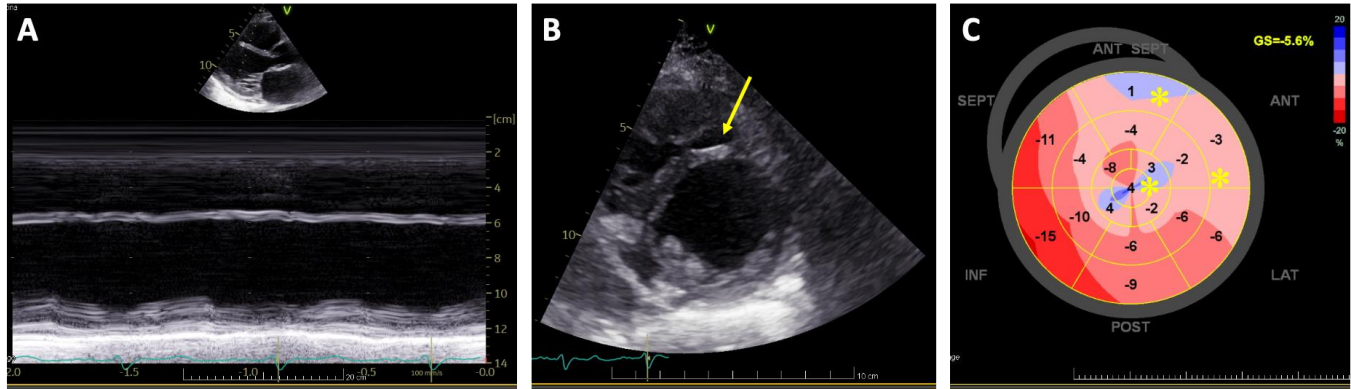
Echocardiography findings: A/Mildly dilated LV with akinesia and thinning of the antero-septal segments; B/ Focal thinning and scar of the antero-septal medial segments (yellow arrow) with preserved thickness of the adjacent myocardium; C/Longitudinal strain pattern showing global severe impairment especially in the antero-septal, anterior and apical segments (yellow asterisks).
